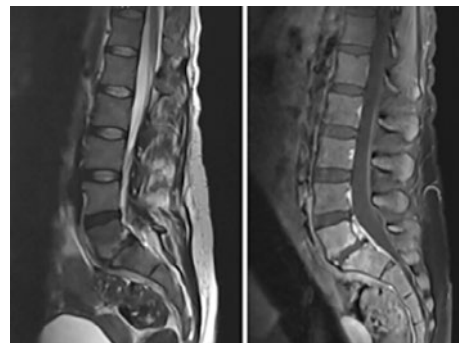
MRI of the lumbar spine (T2 left, T1 right).
